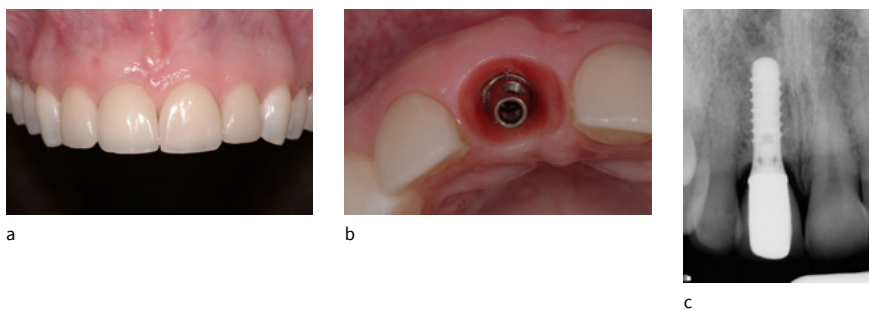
Right-central incisor replaced with an implant-supported crown on a tissue level implant in a patient with thick tissue and high esthetic demands 4 years post-op. a: Facial view showing maintenance of labial contour and interdental papillas without gingival color change. b: Occlusal view with crown off showing thickness of labial tissue. c: Radiograph showing excellent crestal bone maintenance
